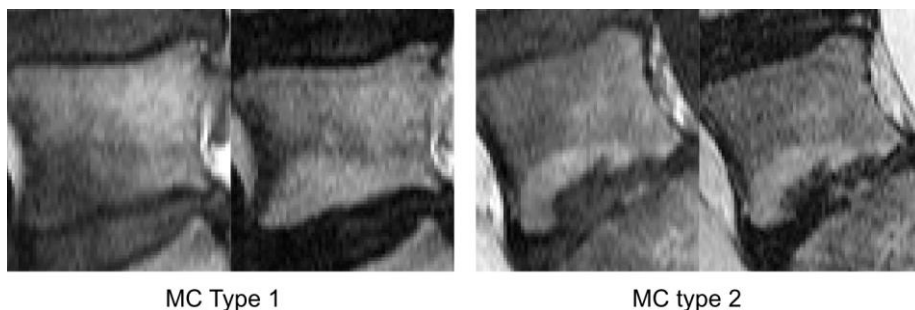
Example of type 1 and type 2 Modic Change (MC) lesions visible on T1-weighted (left) and T2-weighted (right) sagittal MR images of vertebrae.
